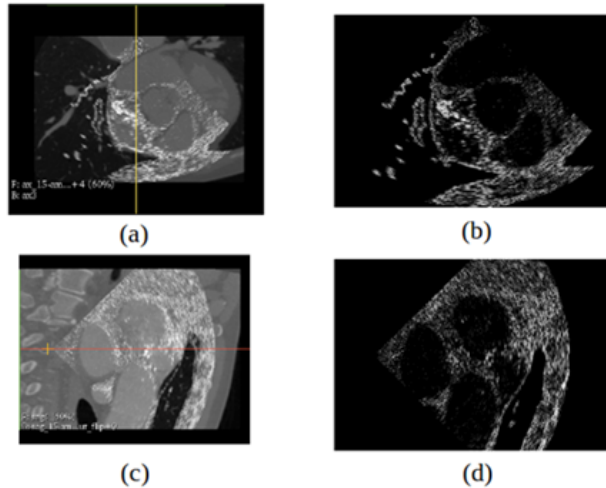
Visualization result (a) resulted CT slice 1, (b) image US1, (c) resulted CT slice 2, (d) image US2
